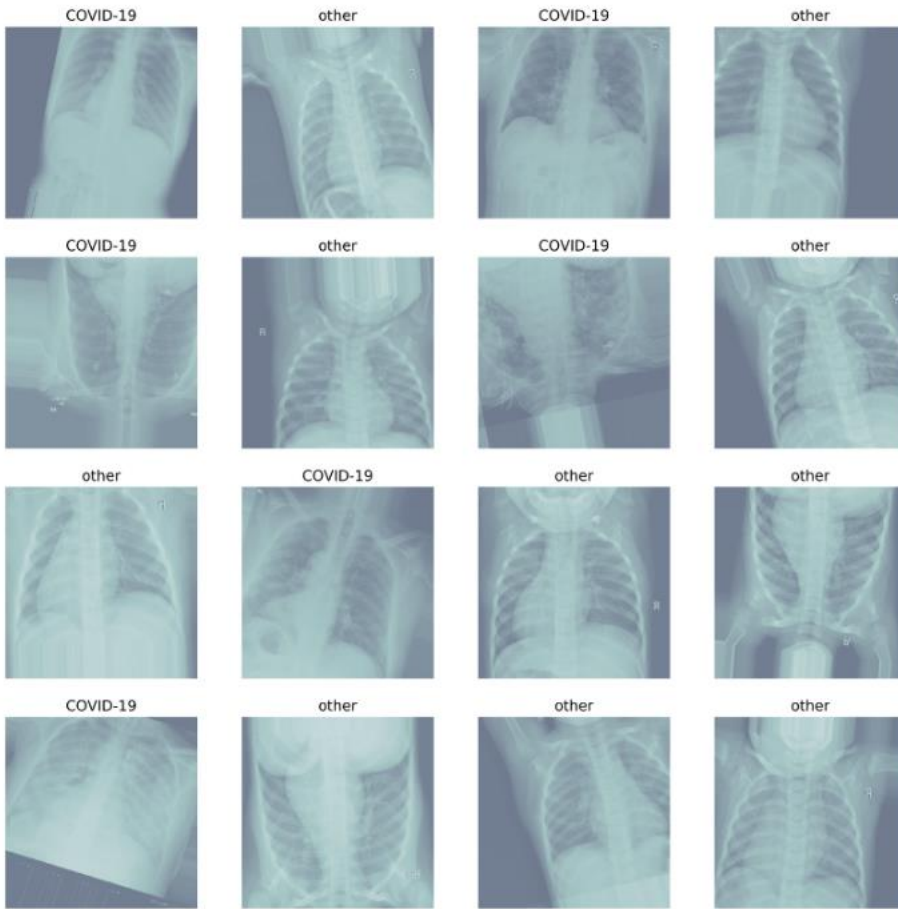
Sample of the labelled X-rays after data augmentation taken from the combined data set of COVID-19 patients and normal patients.
